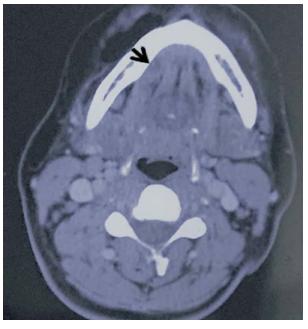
Contrast enhanced CT of floor of the mouth (axial section) shows an enhancing cystic lesion measuring, involving right floor of the mouth, abutting medially the right geniohyoid, genioglossus and the mylohyoid muscles (arrow).
